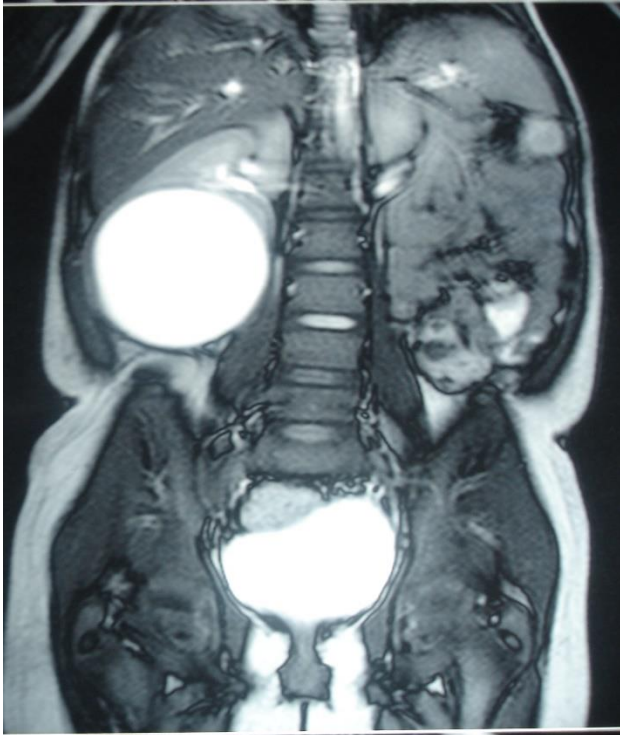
MRI showing unilocular right renal cyst.
